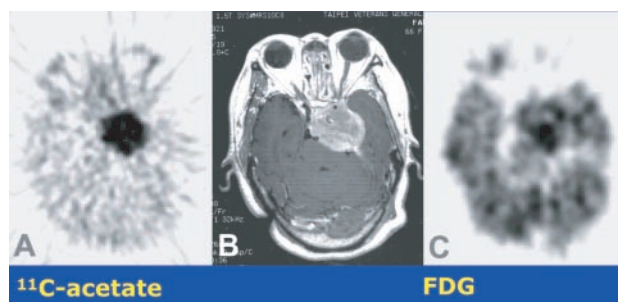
^{11}C -acetate and ^{18}F -FDG PET imaging in a patient with a meningioma.
